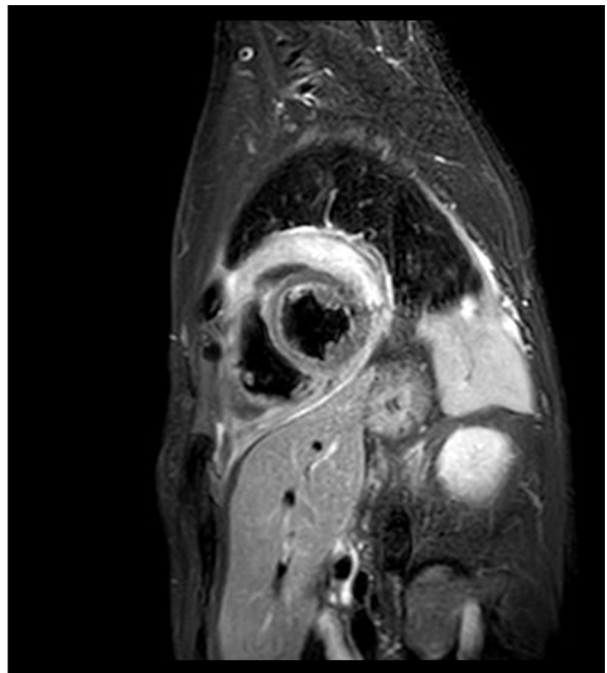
Cardiac MRI after drainage, showing the residual pericardial effusion.
